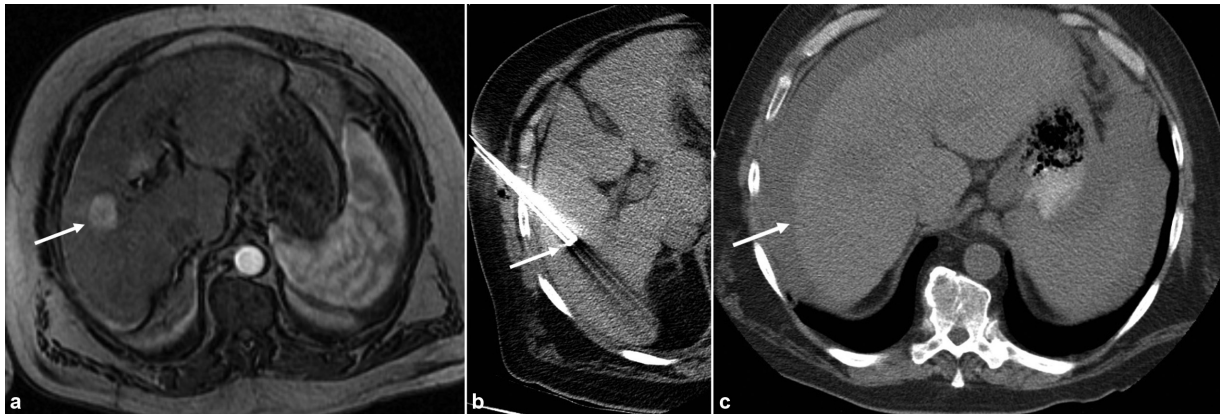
(a) Axial gadolinium-enhanced T1-weighted image of the liver which demonstrated a segment V hepatocellular carcinoma (HCC) (white arrow). (b) Axial CT image at the time of RFA which demonstrates electrode within the HCC (white arrow). (c) Axial unenhanced image of the liver taken 2 days after RFA when patient presented with acute onset of abdominal pain. White arrow indicates new large volume hemoperitoneum.
